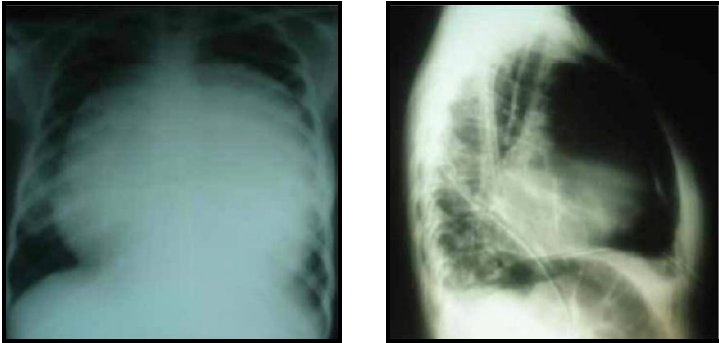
Plain chest radiograph of patient with effusive-constrictive pericarditis. a) Anteroposterior view showing globular enlargement of cardiac silhouette. b) Lateral view with pericardiostomy tube in-situ and calcification of anterior pericardium.
